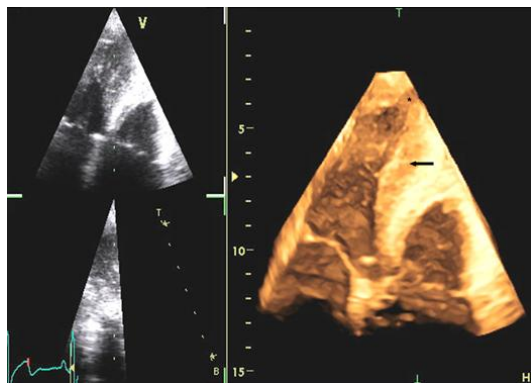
4 chamber 3D echocardiographic view, in the Mayo format, showing LV apical hypertrophy (Arrow) and presence apical pouch (Asterisk).
